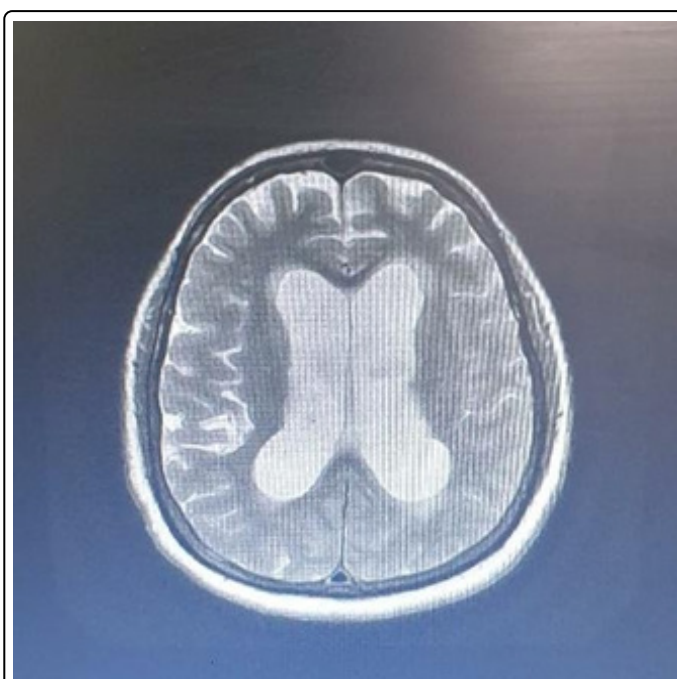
MRI brain screening showed dilated ventricles.
